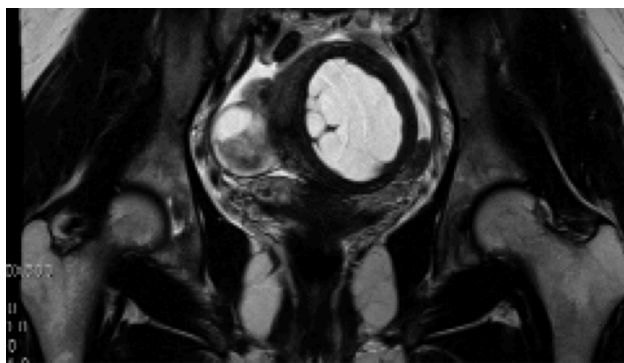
Subserosal myoma (6.3 cm) with cystic degeneration is observed on MRI.
